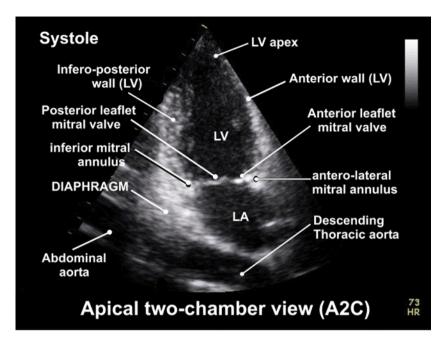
Annotated apical two-chamber view (A2C).
